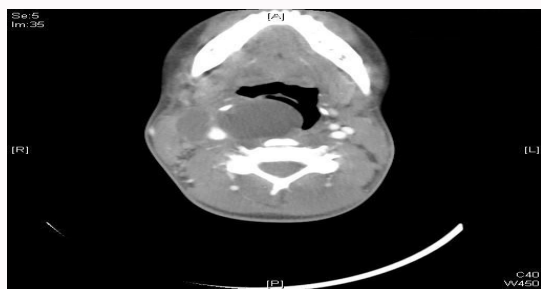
CT neck- Right parapharyngeal abscess.
